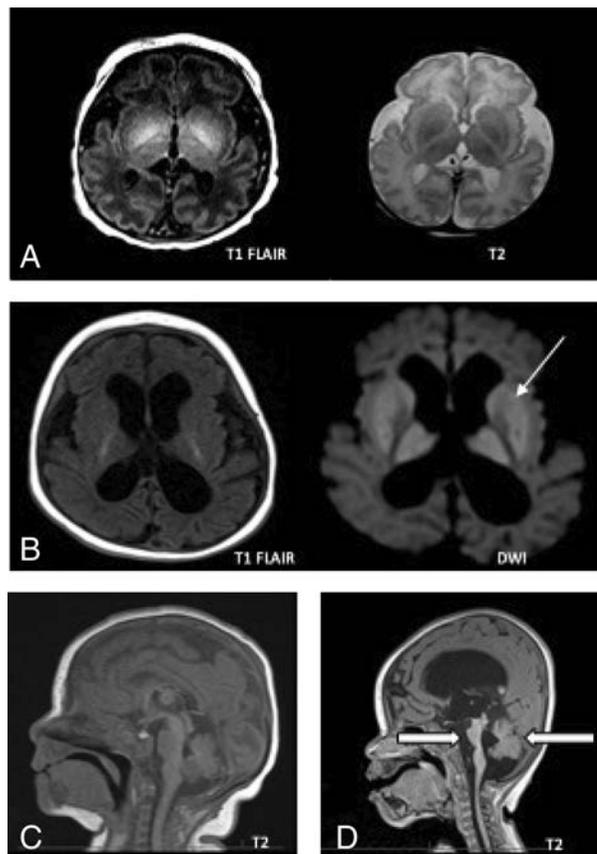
Serial brain MRI of sibling 1 demonstrating progressive cortical and brainstem atrophy at (a) birth and (b) 4 months of age. Persistent diffusion restriction in the bilateral basal ganglia is also seen (thin white arrows). Midline sagittal images comparatively at (c) birth and (d) 12 months of age demonstrates atrophy of the pons and cerebellum (thick white arrows), consistent with pontocerebellar hypoplasia. Abstract 210
